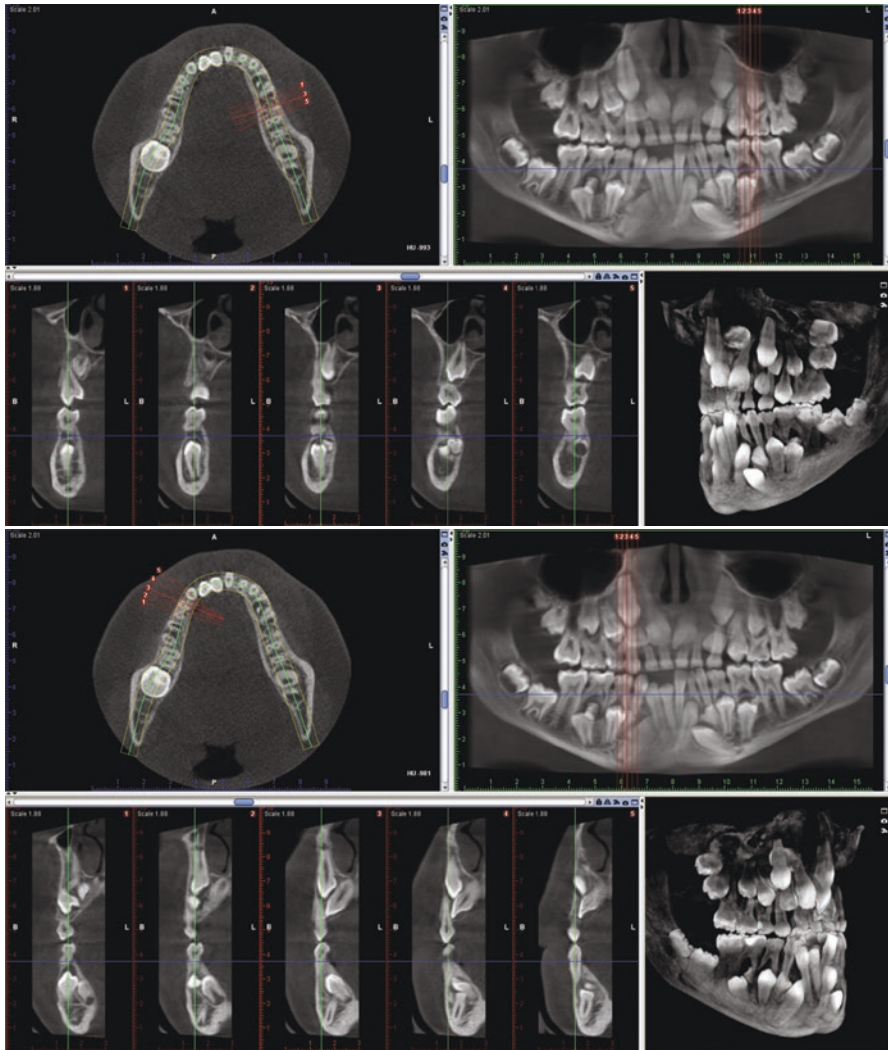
This is a cone beam computed tomography of an 8-year-old girl with cleidocranial dysplasia, taken for surgical planning purposes to determine which supernumerary teeth were going to be sacrificed for extraction. The top image shows a couple of slices through the left-hand side of the patient’s jaws, while the bottom images show the patient’s right-hand side. Notice the supernumerary teeth on the lingual side in the mandible which can easily be missed on a traditional panoramic radiograph. The three-dimensional reconstructed radiographs can help the surgeon in this case to visualize the impacted supernumerary teeth better in relation to the erupted teeth
